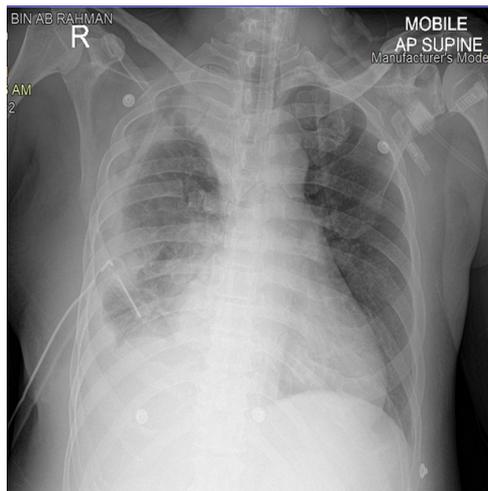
Chest X-ray showed marked improvement of right pleural effusion, with chest tube in situ.
